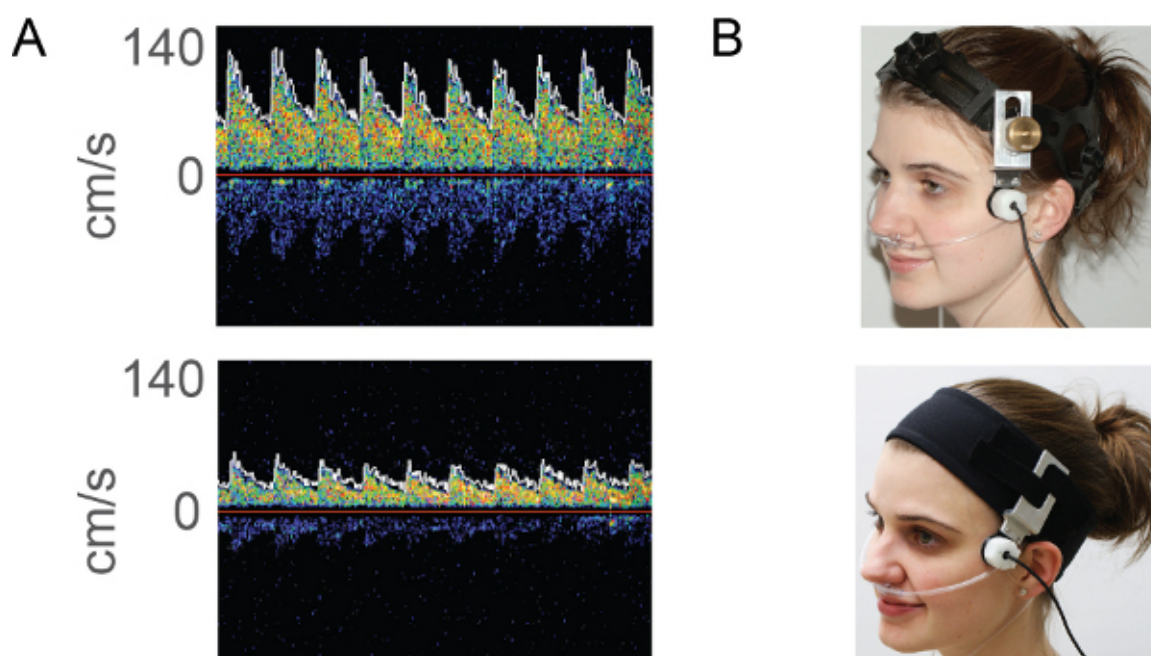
Middle cerebral artery blood flow velocity measurement. A. A 2MHz ultrasound probe is positioned on the transtemporal window overlying the middle cerebral artery. An example showing middle cerebral artery blood flow velocity is shown in the top panel. The bifurcation point, with the anterior cerebral artery waveform just visible as a negative deflection, enables confident identification of the middle cerebral artery. The bottom panel shows an example from the posterior cerebral artery. Although the flow profile is similar to the middle cerebral artery, the mean velocity is lower and insonation depth greater, enabling ease of discrimination between the two vessels. B. Once in place the probe is secured in position using either a plastic headset (upper) or fabric headbands (lower).
